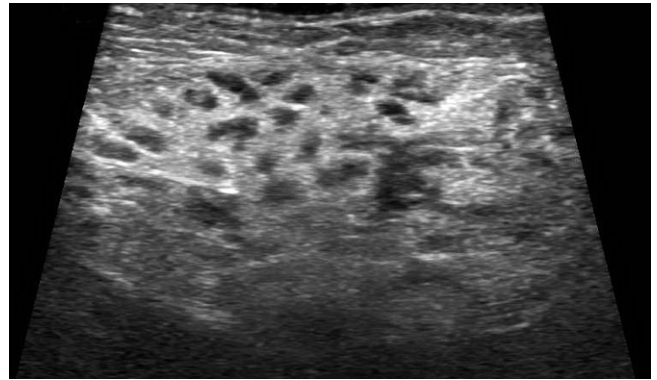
The longitudinal gray scale sonogram of the left submandibular gland also contains multiple small hypoechoic nodules scattered diffusely throughout the gland.
